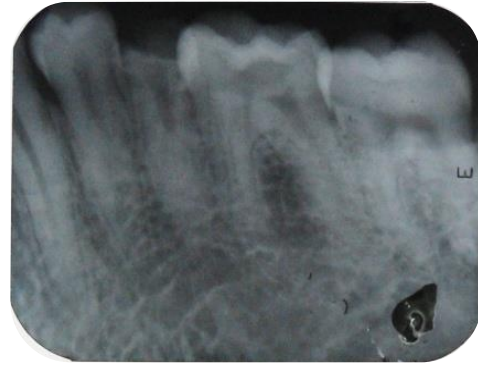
An angled pre-operative radiograph
